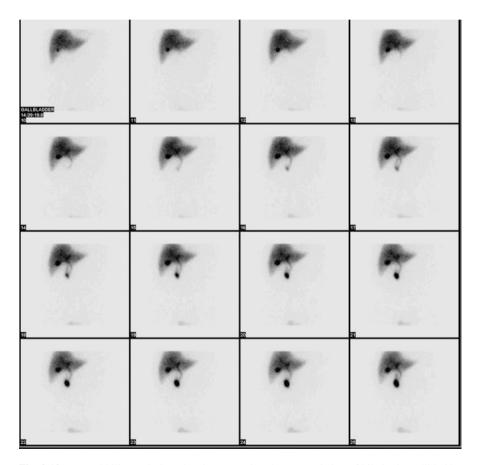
Normal biliary scintigraphy, demonstrating the accumulation of bile in the gallbladder and normal flow through the CBD to the duodenum. Reprinted under terms of Creative Commons license from Myo Han. HIDA scan. https://upload.wikimedia.org/wikipedia/commons/9/94/HIDA.jpg. CC BY 3.0 (http://creativecommons.org/licenses/by/3.0)
